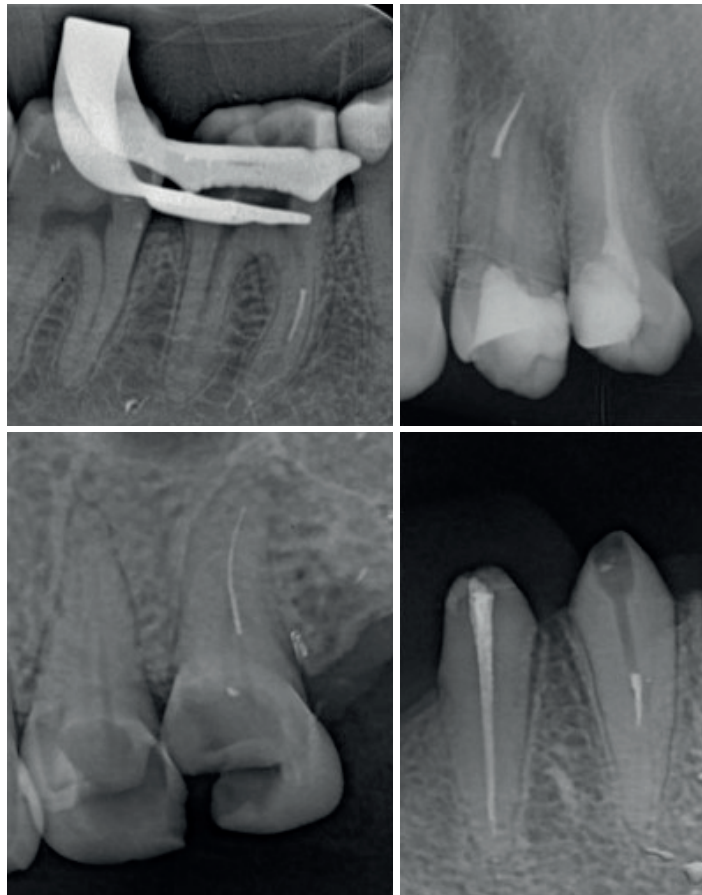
Periapical X-ray images of broken files.
